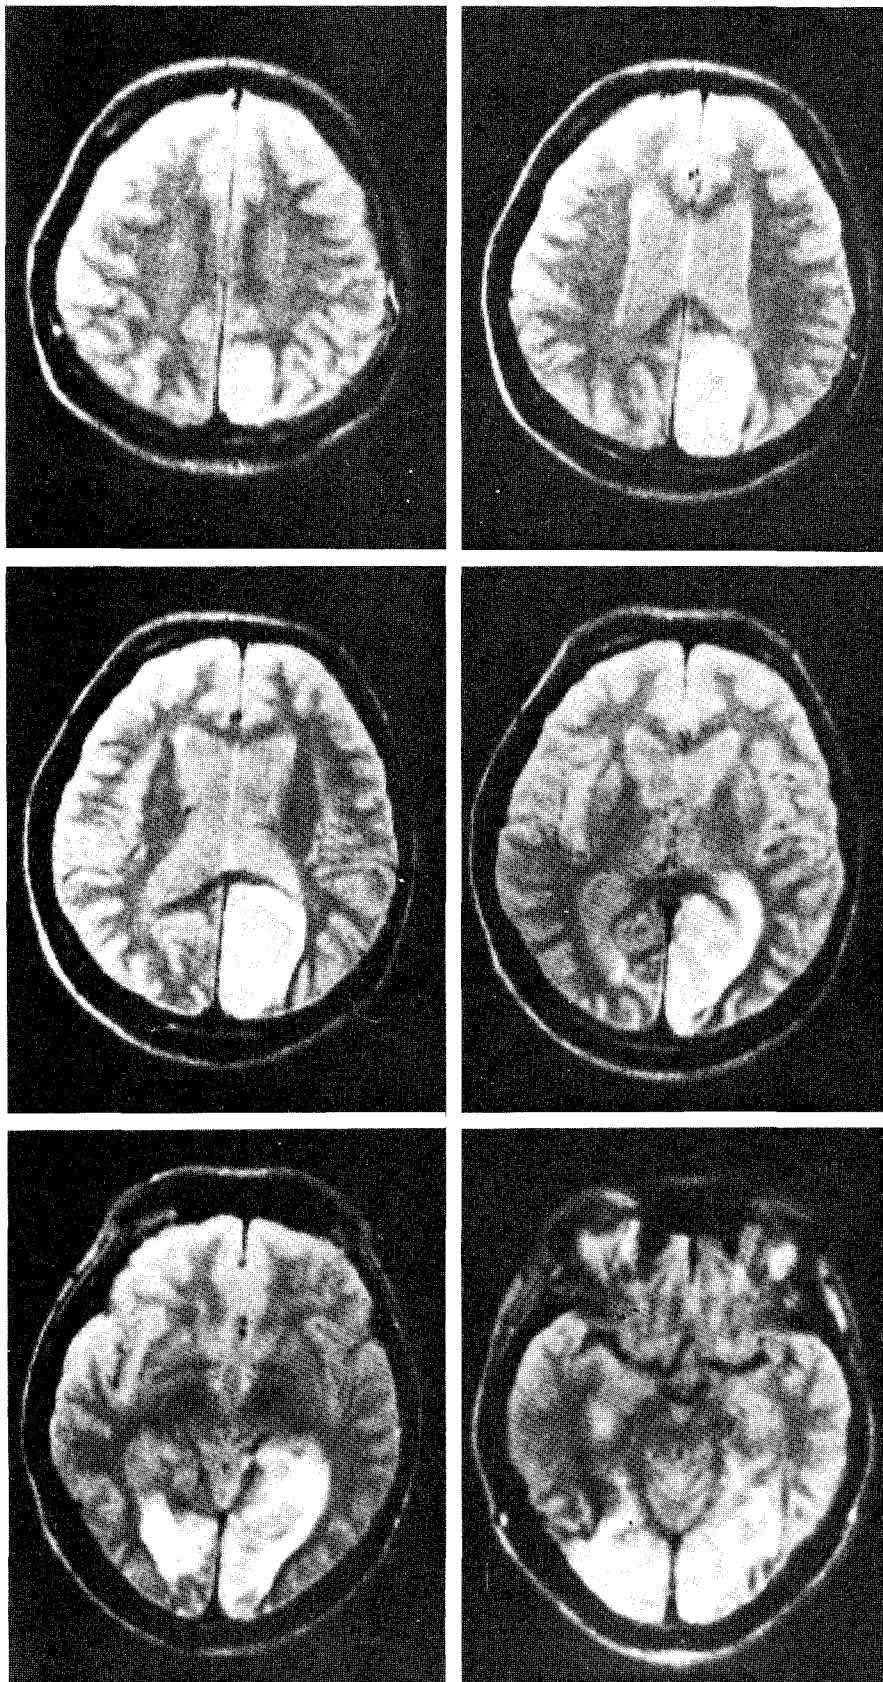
An MRI obtained on the second hospital day, approx. 12 days following the onset of neurological dysfunction. The *left* hemisphere, on the *right* of each image, demonstrates an extensive occipital lesion in all sections. The *right* hemisphere demonstrates a smaller, deep lesion most prominent in the first section of the bottom row. MRI parameters: TR = 2150 ms; TE = 60 ms; slice thickness = 0.75 cm.
